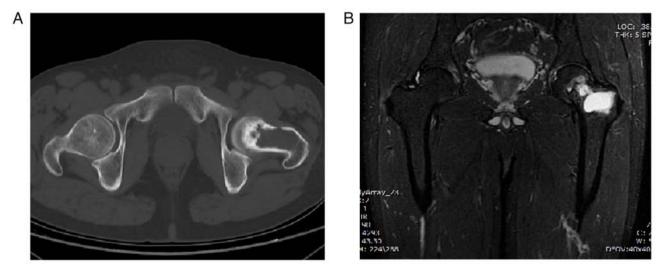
(A) Computed tomography image displaying a cystic shadow in the left femoral head and femoral neck with sclerotic margins, with a high probability of ABC. (B) Magnetic resonance imaging indicates an abnormal signal shadow in the left femoral head and femoral neck, further confirming the possibility of ABC. ABC, aneurysmal bone cyst.
